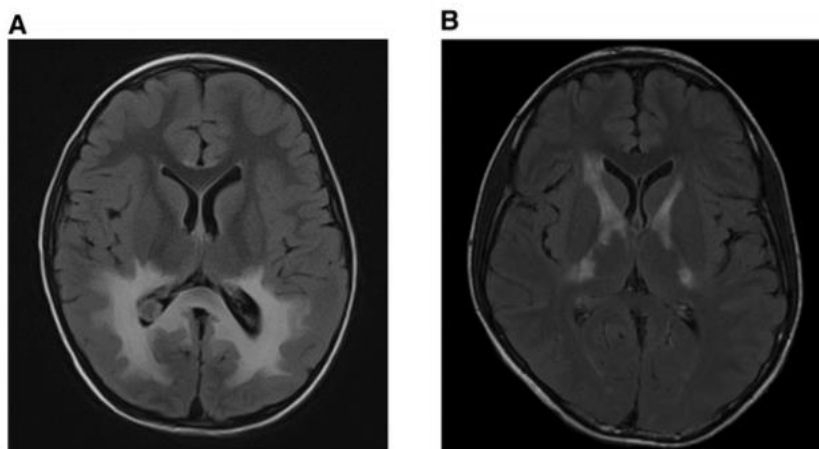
(A) Brain MRI (axial images; FLAIR sequence) showing abnormally increased signal in the splenium of the corpus callosum, the parieto-occipital white matter, the visual pathways (optic radiations and lateral geniculate bodies), as well as the medial geniculate bodies of auditory pathway and the posterior limbs of the internal capsules. The demyelinating lesions are extensive and correspond to an advanced disease stage. (B) Brain MRI (axial images; FLAIR sequence) showing abnormally increased signal involving the posterior and anterior limbs of the left and right internal capsule. From (Kemp et al., 2012).
